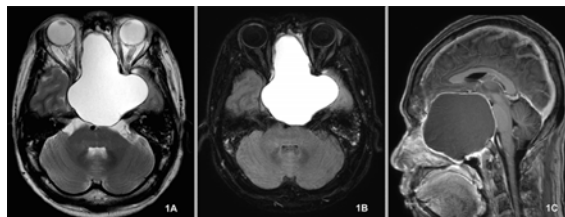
1A) T2 Axial view, 1B) FLAIR axial view, 1C) T1, Post Gadolinium, Sagittal view revealed large rim enhancing cystic mass with the epicenter located at anterior-central skull base.
